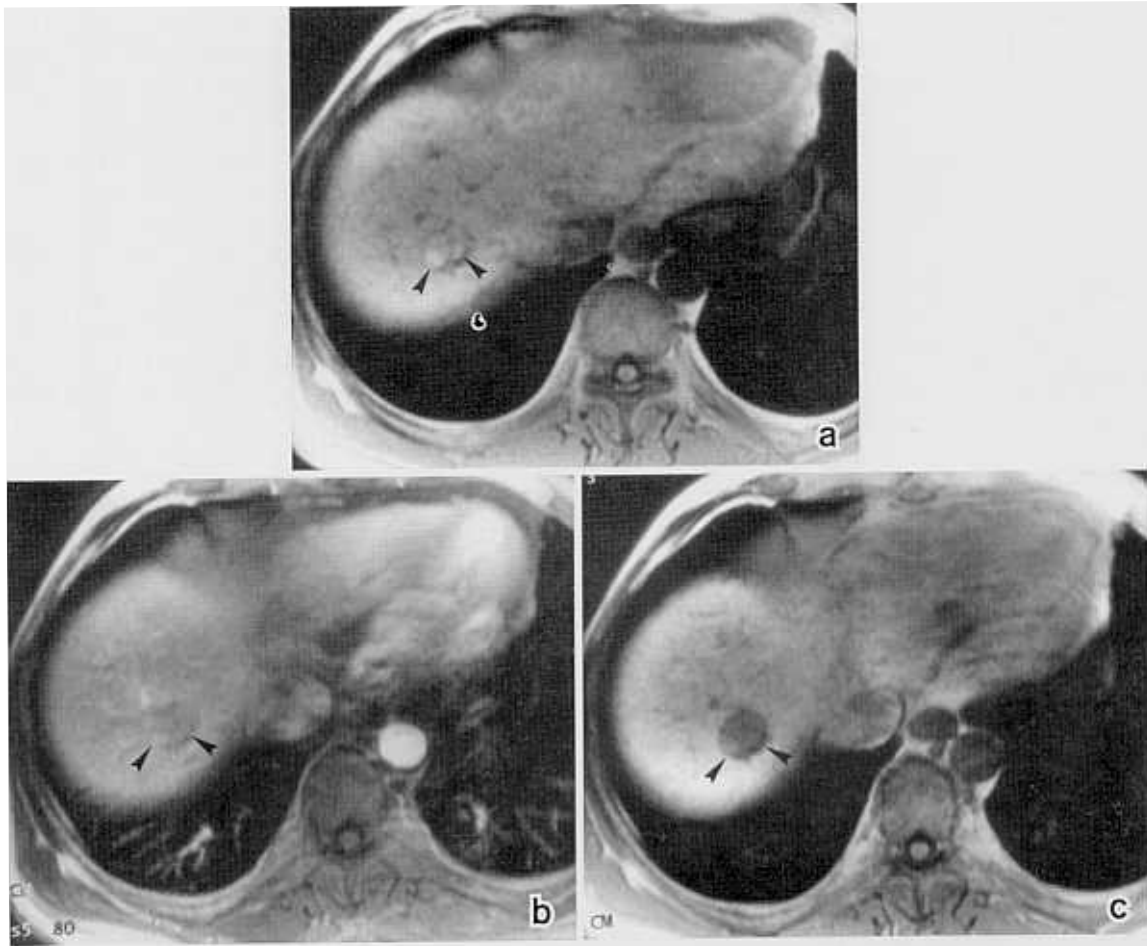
Low-grade dysplastic nodule in a 51-year-old man with liver cirrhosis. (a) Unenhanced T1-weighted MR image shows a high signal intensity nodule (arrowheads) in right lobe of liver. (b) Contrast-enhanced MR image obtained during first phase (arterial dominant phase), 10 sec after intravenous administration of contrast agent was started, shows an uncertain contrast enhancement of right lobe lesion (arrowheads). (c) MR arterial portogram obtained during first phase of imaging 20 sec after initiation of contrast material injection via splenic artery shows a nodular perfusion defect. Follow-up CT demonstrated no corresponding iodized oil uptakes (not shown) and a low-grade dysplastic nodule was confirmed by subsequent gun-needle biopsy.
